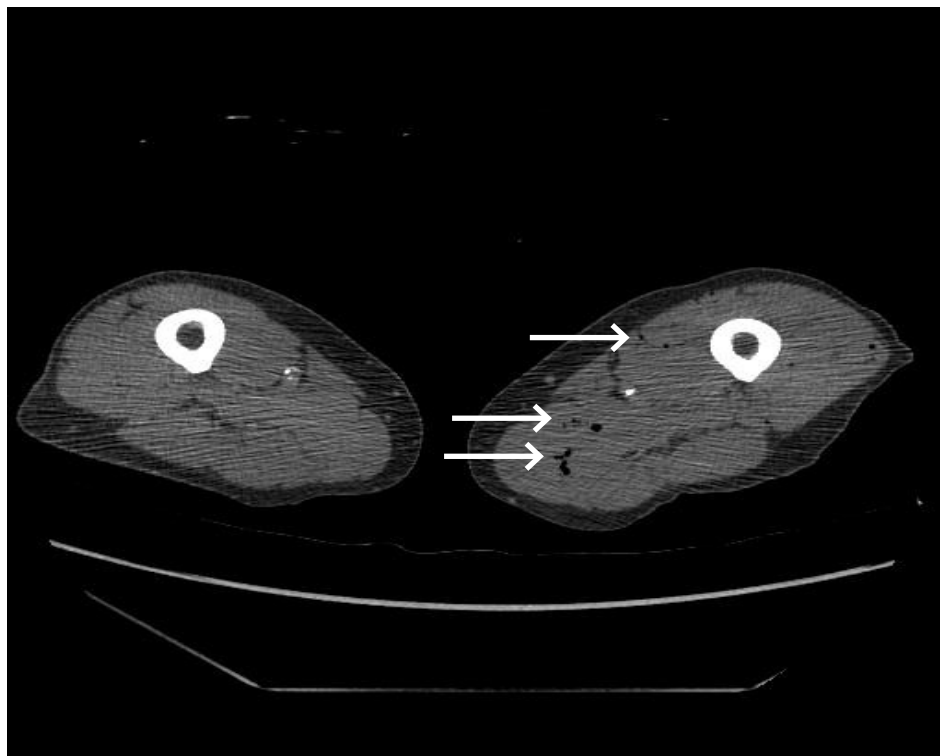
Computed tomography angiography of bilateral lower extremities displaying intramuscular gas, signifying myonecrosis in both thighs (arrows).
